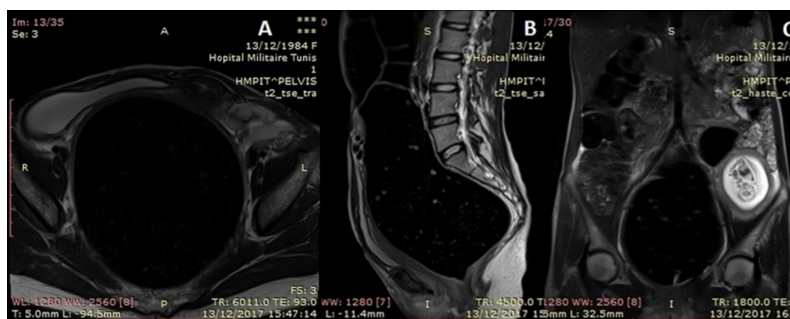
Abdominal MRI—transversal (A), sagittal (B) and coronal (C) T2-weighted slices—showing the rectum to the rectosigmoid junction massively distended, measuring 14 cm in axial diameter, and is occupied by a large fecaloma.
